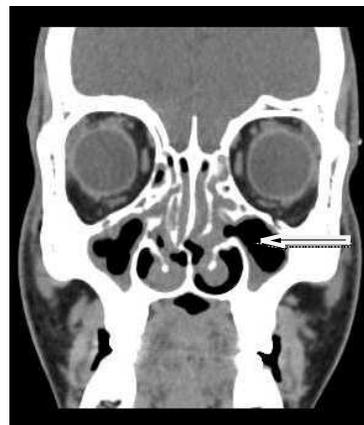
CT Paranasal sinuses-Mucosal thickening
